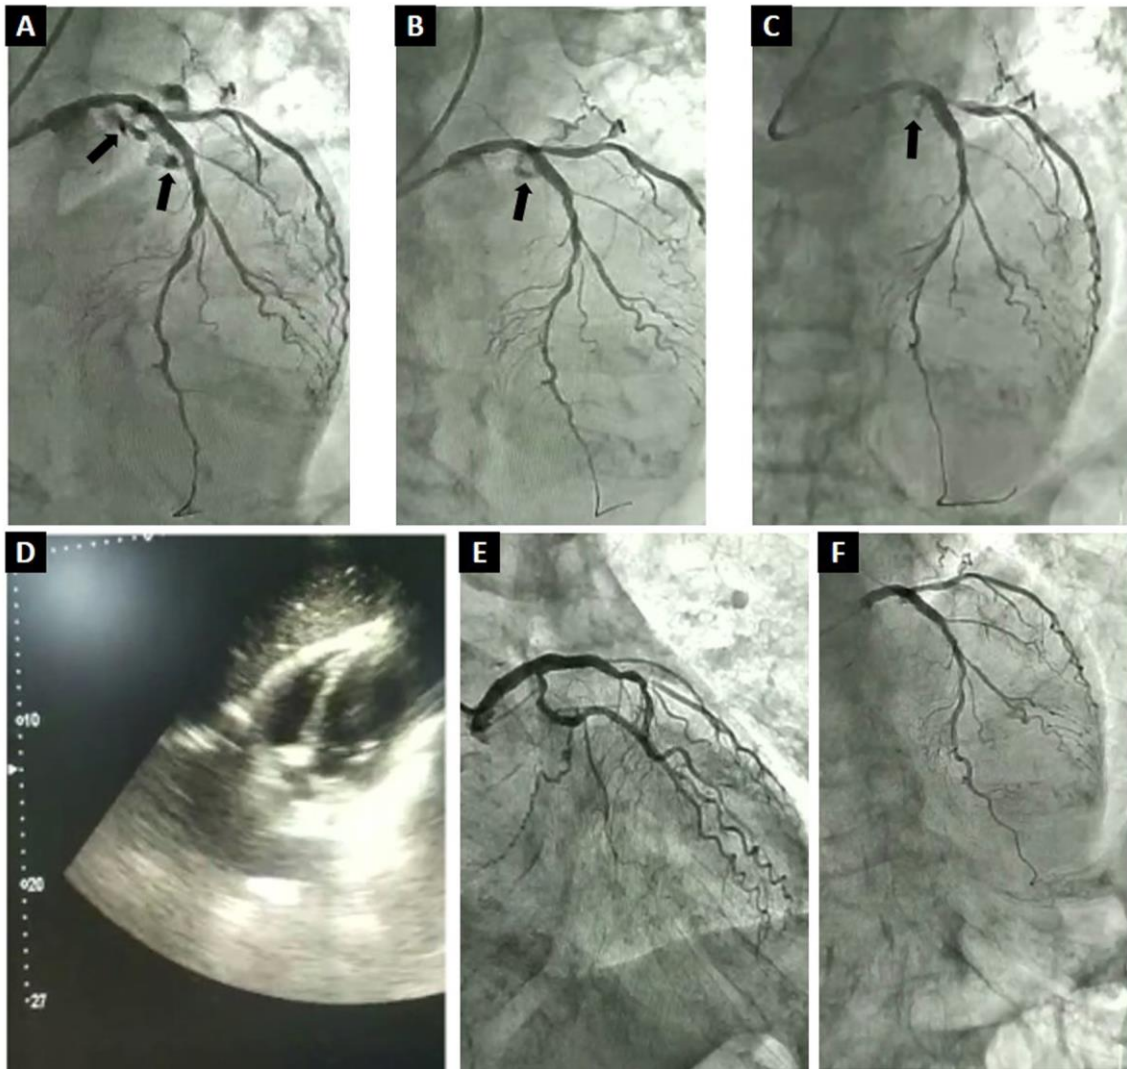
Ellis type III perforation in LAD and LM (A) after post dilatation, LAD perforation sealed after balloon tamponade with persistence of LM perforation (B), slight trickling after regular DES deployment in LMCA (C), post perforation echocardiography (D), recheck angiography after 24 hours did not reveal any extravasation (E, F)
